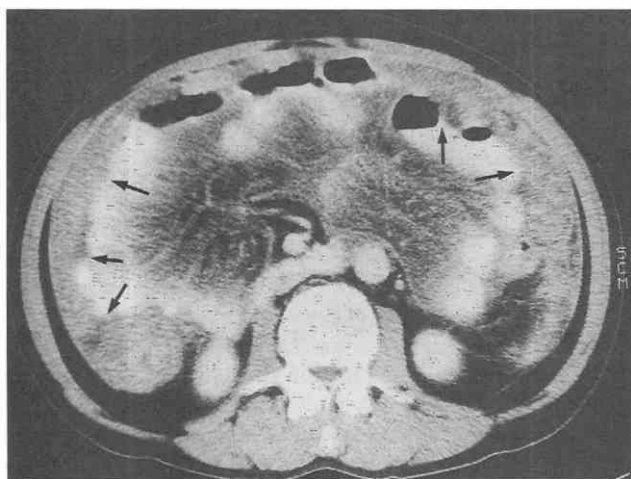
Peritoneal lymphomatosis. CT scan shows omental cake (arrows) and diffuse mesenteric infiltration.
